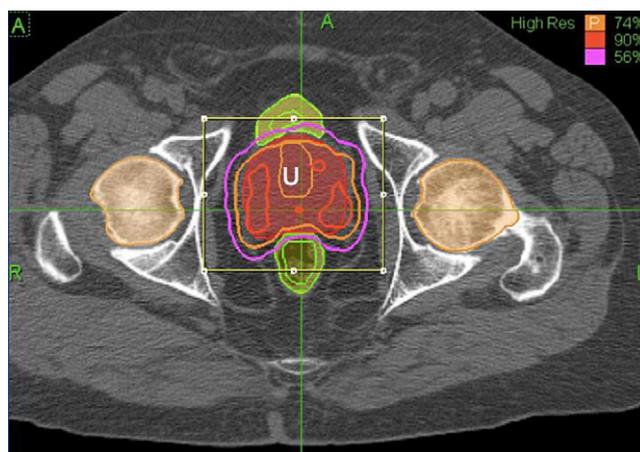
Sample stereotactic body radiotherapy (SBRT) dosimetric plan. The dose delivered for SBRT boost was 19 Gy in 2 fractions prescribed to the 74% isodose line. The 90% isodose line represent 120% of the prescription dose (22.8 Gy), and the 56% isodose line represents 75% of the prescription dose (14.25 Gy). The urethra (U) was defined by T2 axial MRI images on a 3T scanner. The V75% for bladder and rectum was <2 cc. The V120% for the urethra was <10%.
